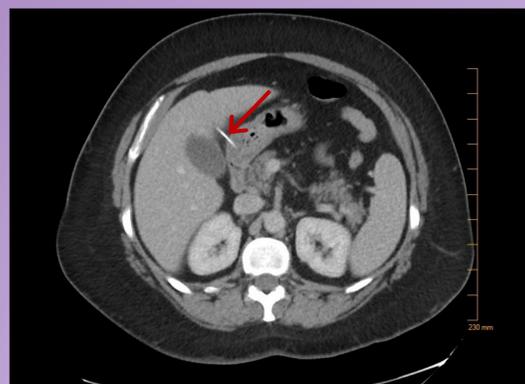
CT Abdomen Pelvis revealing a density extending from the stomach toward the liver
